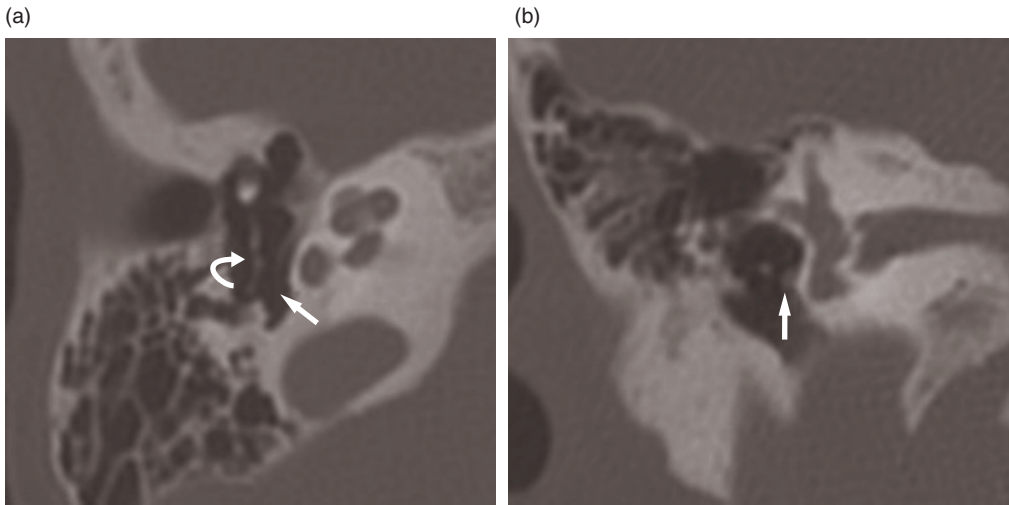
Axial (a) and coronal (b) CT scans. Tympanic dehiscence of the facial nerve (arrow); incudo-stapedial dysplasia (curved arrow) (reproduced from Calzolari F., 2006,⁶ with permission of Omega Edizioni).
